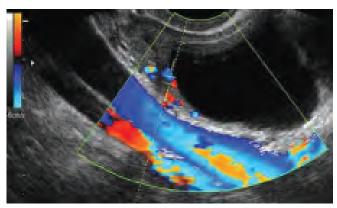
Simple ovarian cyst as seen by color Doppler ultrasound. Note the smooth surface of the cyst and extraovarian vessels, while no vascularity is detected within the cystic wall. Color Doppler may help to avoid penetration of the surrounding vessels
